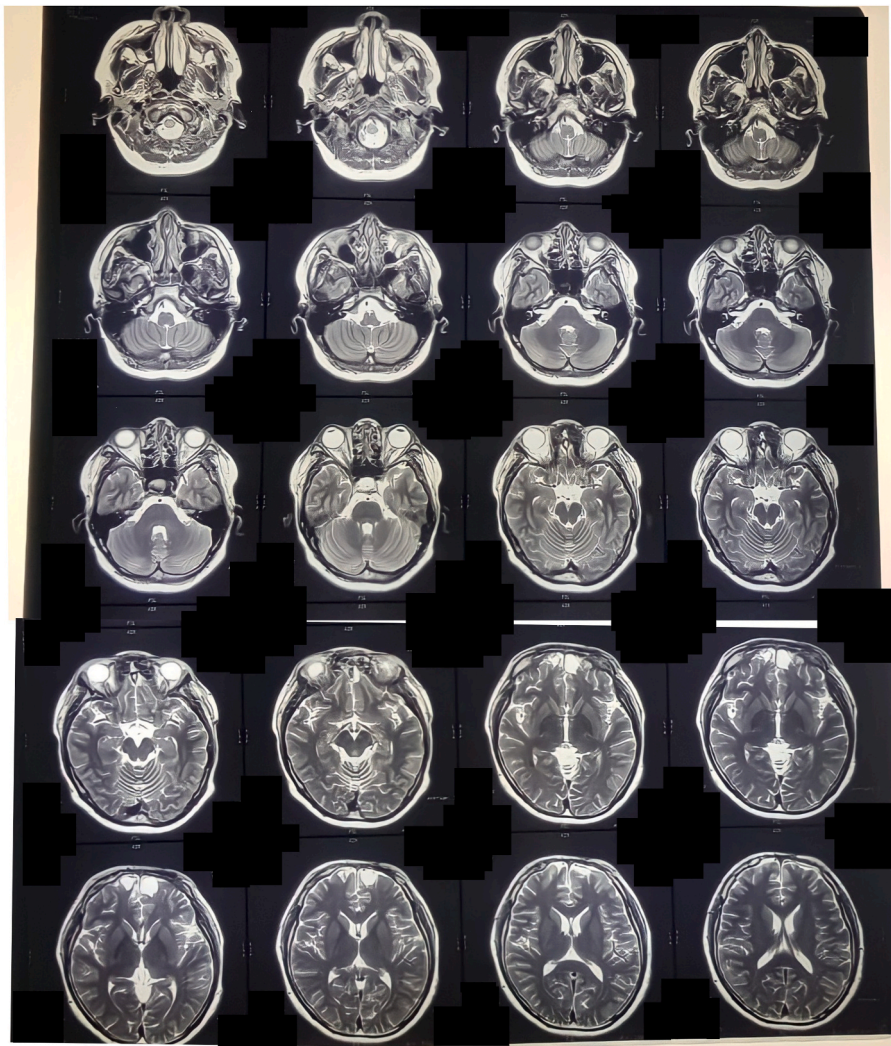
Brain magnetic resonance imaging (MRI).
